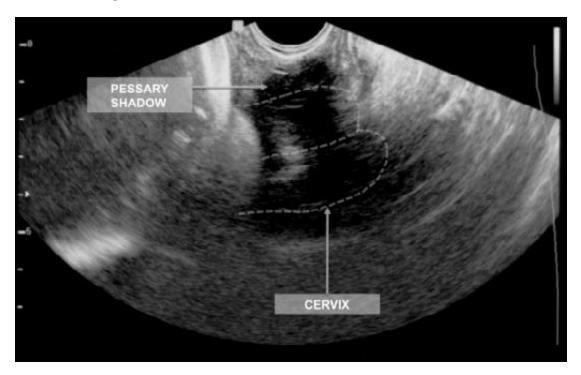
Ultrasound visualization of cervical length in women using a cervical pessary (new technique).
